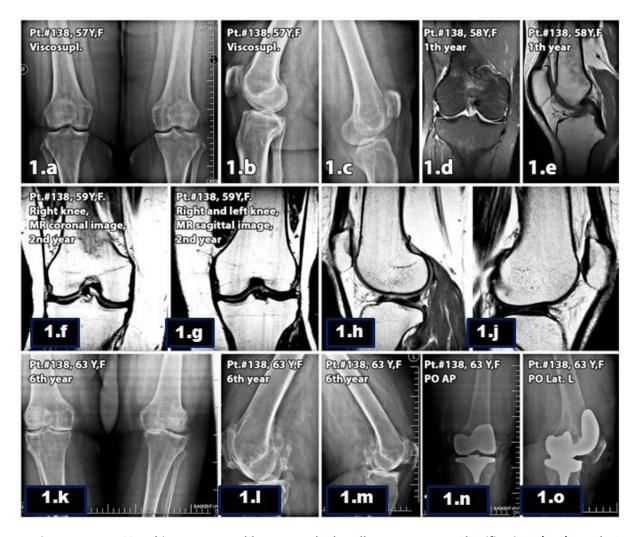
Pt.#138, This 57 years-old woman had Kellgren-Lawrence Classification (KLC) grade-2 degeneration at first admission. (a) AP x-ray of the knee prior to viscosupplementation three times every 6 months with Hyalen-L, (b-c) lateral x-rays of both knees, (d-j) Coronal and sagittal MR scans of both knees at 1st and 2nd years, (k-m) standing AP and lateral x-rays of both knees, (n-o) AP and lateral x-rays following total knee arthroplasty at 6th years.
